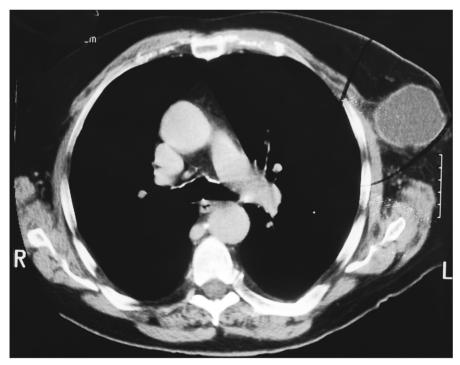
CT scan shows metastatic mass in axilla from carcinoma of the stomach.
